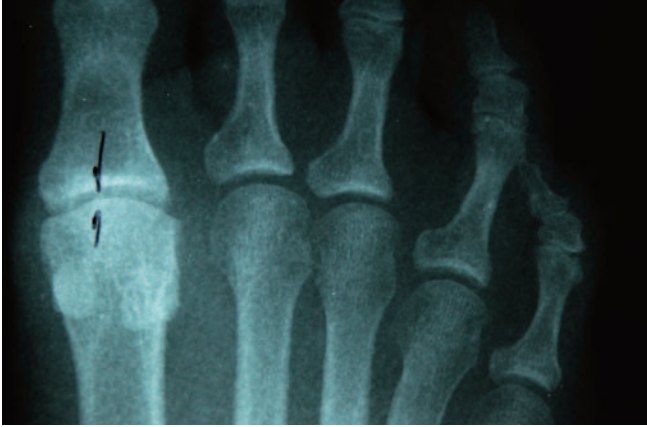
Case Study 3. Preoperative AP radiograph.
